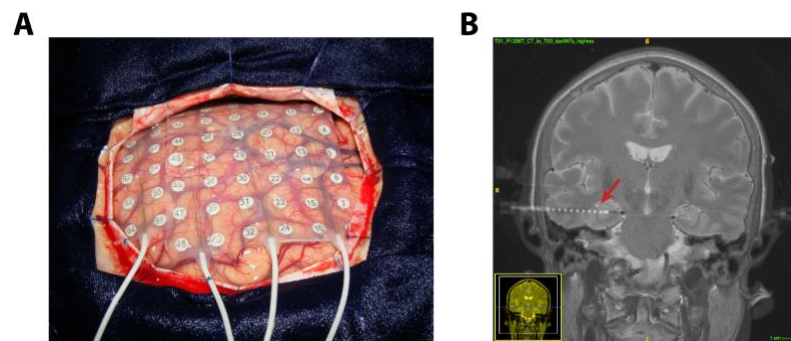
Intracranial EEG. A. Surgical placement of a grid electrode in a patient with medication-resistant epilepsy. Grid electrodes are placed subdurally, allowing direct recording of electrical potentials from the cortical surface (electrocorticography; ECoG). B. Post-operative CT scan coregistered to pre-operative T1 MRI, highlighting the placement of a linear depth electrode in the right temporal lobe (red arrow). Depth electrodes enable the recording of LFPs from the medial temporal lobe. Image in (a) reproduced from <https://mnepilepsy.org/services/>.
